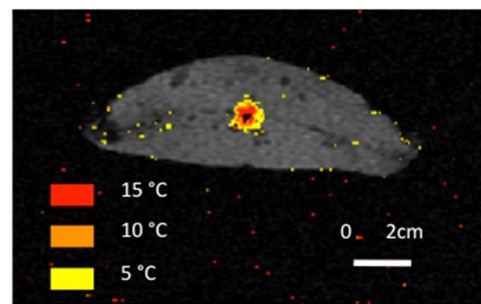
Real time MRI thermometry data demonstrates temperature profile of adjacent tissue immediately after ablation.
